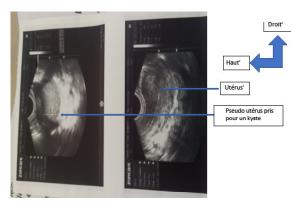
Ultrasound Images Showing an Empty Uterus and Pseudosac Image
